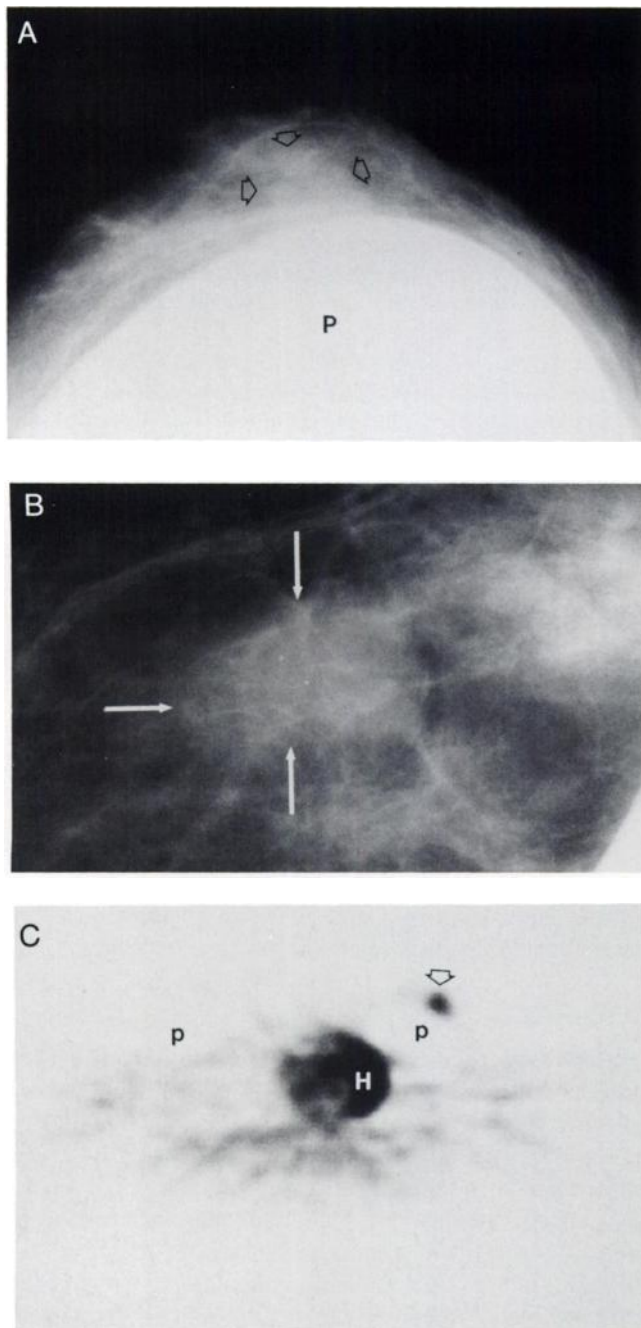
(A) Craniocaudal mammogram of the left breast shows large prosthesis (P) and adjacent mass (arrowheads). (B) Magnification coned compression displacement view of a left breast mass. The 1.5 × 1.0 cm mass (arrows) is moderately well circumscribed and has two microcalcifications. (C) Transverse FDG-PET scan at the level of the mass demonstrates an FDG-avid nodule (arrowhead) in the left breast beyond the prosthesis (P), which does not accumulate ^{18}F . Normal intense FDG uptake in the heart muscle is noted (H).
